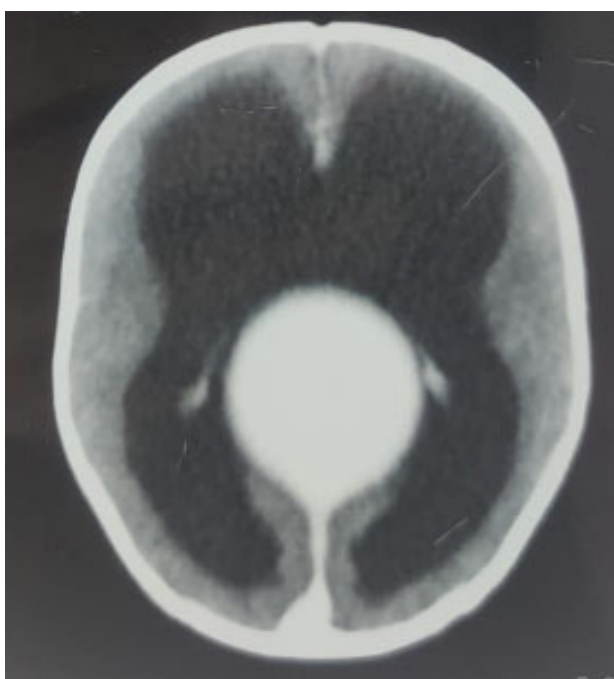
CT image of 6 month infant - increase in size of Aneurysm of vein of Galen &amp; dilated lateral ventricles
